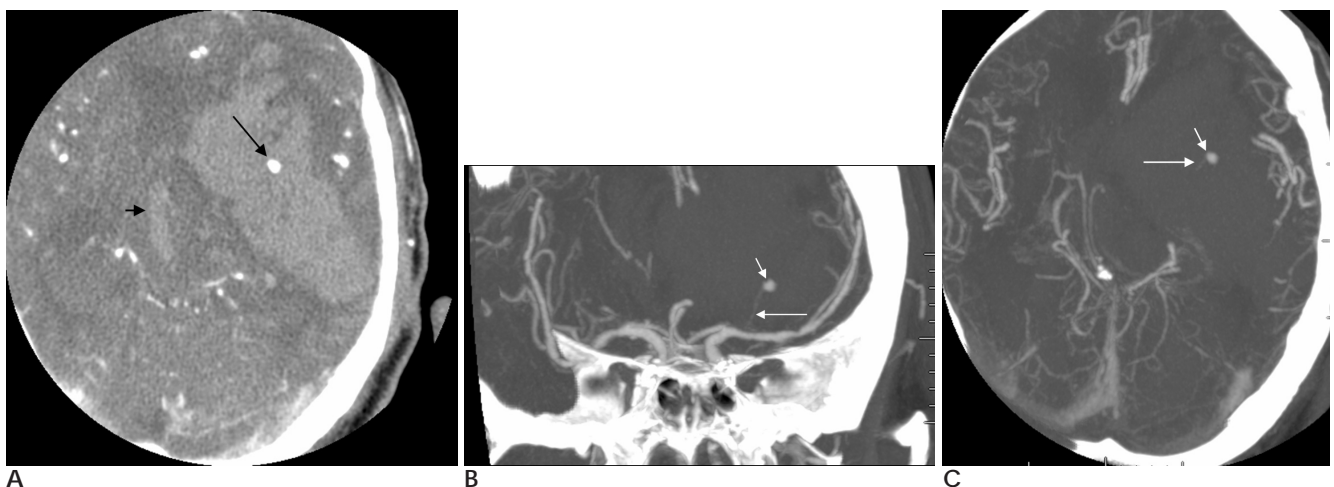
Brain CT angiography with Type A contrast extravasation in a 88-year-old man with a huge acute spontaneous ICH.
